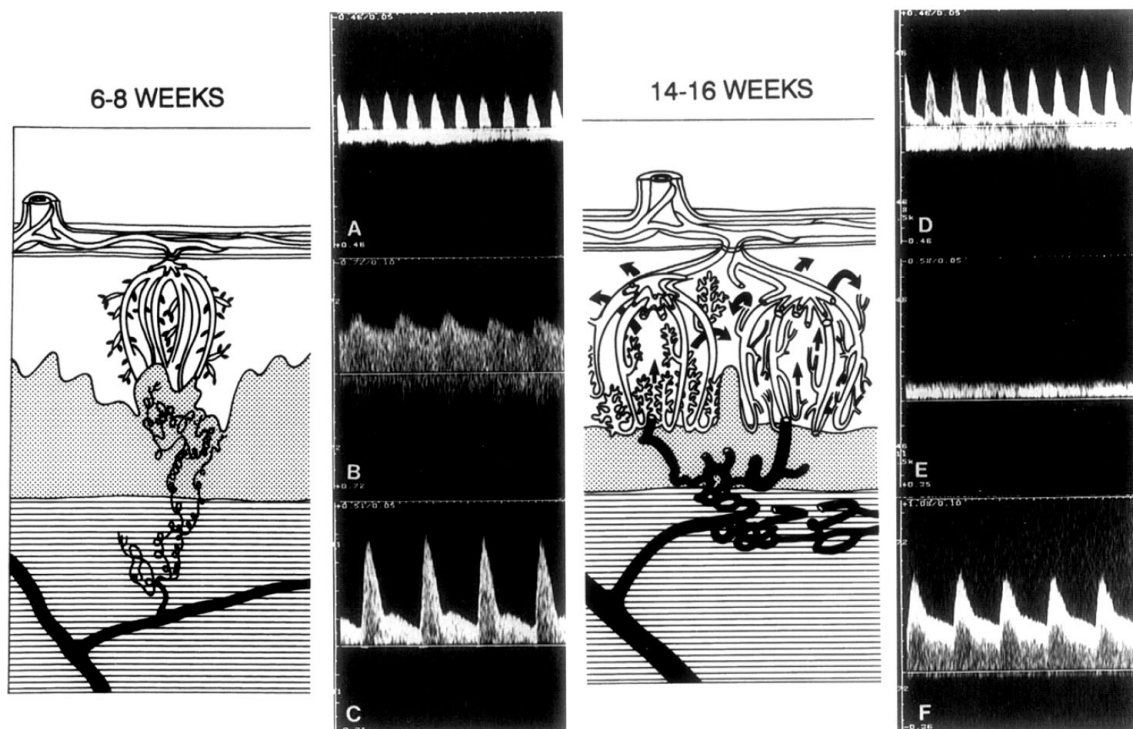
Ultrasound techniques demonstrating the change in pulsatility patterns caused by the trophoblast remodeling of the spiral arteries and the onset of the maternal intervillous circulation: before (on the left) and after (on the right). The ultrasound measurement were made in: A, D — the umbilical cord, C, F — the main uterine artery, B — the spiral artery, E — the intervillous space. The horizontal and vertical axes in all plots correspond to time and linear blood velocity respectively. Although not all the pulsatility figures have the same scale, note the change in the shape of flow velocity waveforms. See also discussion in Section 1.3.1 and Fig. 1.12. Reproduced from Jauniaux et al. (1995)
